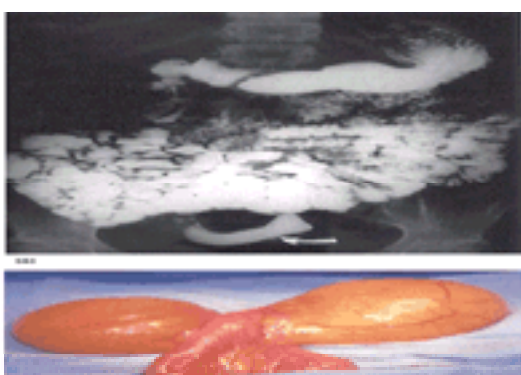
(a) A barium upper-gastrointestinal series from an 18-year-old woman with symptoms of intermittent intestinal obstruction and a weight loss of 11.4 kg (25 lb); an abnormal loop of intestine is present in the distal ileum (arrow). (b) Mesenteric cyst removed at exploration. Preoperative ultrasound examination also demonstrated a cystic mass in the lower abdomen. The thin wall of the cyst reveals the serous colour of its contents. The cyst was intimately adherent to the bowel, and its removal required a segmental resection of the involved intestine with the cyst.
